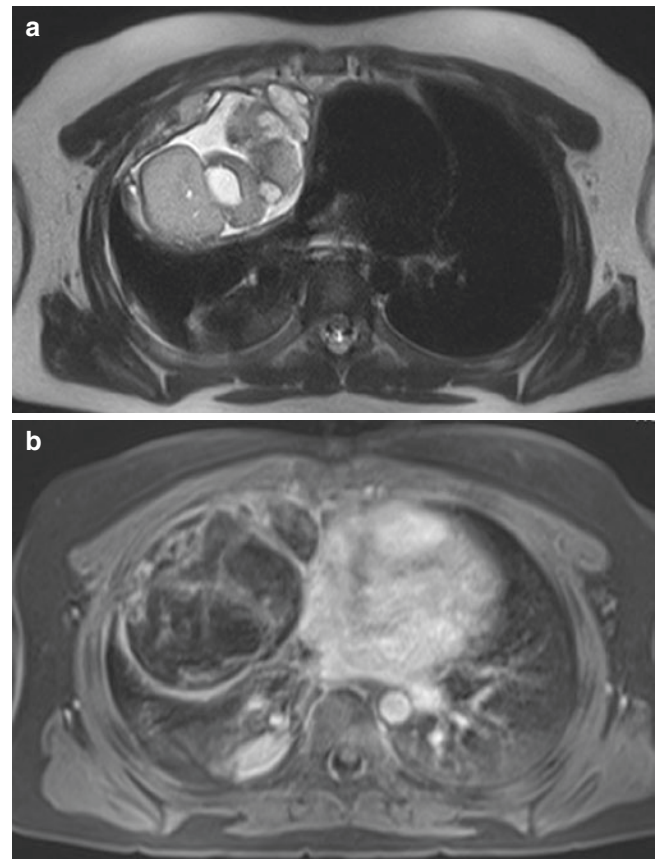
A 14-year-old girl with mediastinal teratoma. (a) Axial T2-weighted HASTE MR image demonstrates a mediastinal mass with inhomogeneous signal intensity due to cystic and solid components. (b) Axial contrast-enhanced T1-weighted THRIVE MR image with fat suppression shows hyperenhancement of the wall and soft tissue components of the mass
